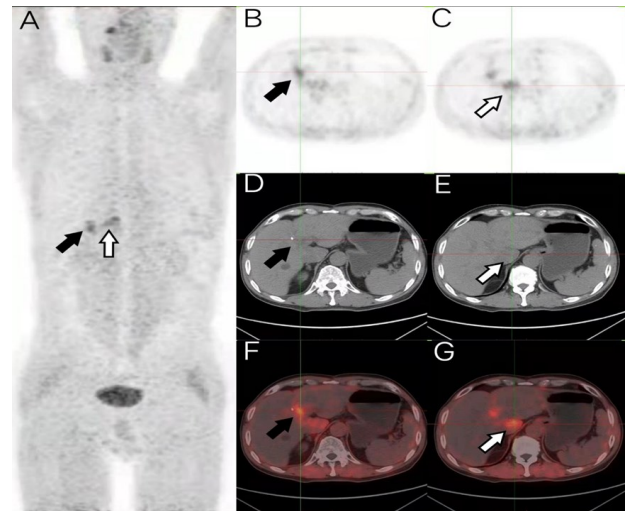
With the consent of the patient, a ⁶⁸Ga-FAPI PET/CT scan was conducted five days following the ¹⁸F-FDG PET/CT. (A) The maximal intensity projection image, and axial view images of PET (B, C), CT (D, E), and fused PET/CT (F, G), revealed higher uptake compared to ¹⁸F-FDG in caudate lobe (C, E, G hollow arrow SUV_{max}:5.3) and in the hilum of the liver (B, D, F arrowhead; SUV_{max}:5.2). In addition, some small round hypodense or isodense nodules without increased uptake in the liver were found.
